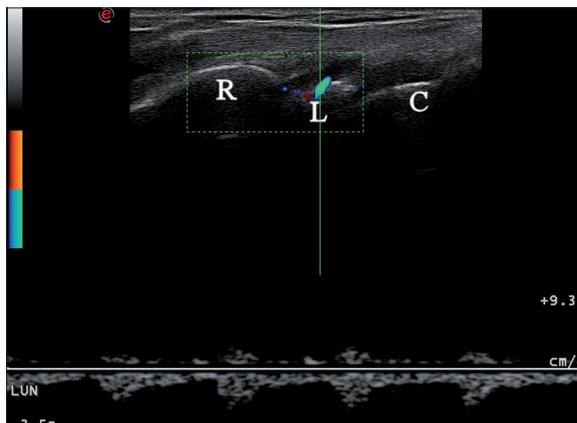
Spectral Doppler wave image obtained from blood vessel seen in lunate erosion, low-resistance type. Dorsal sagittal US image; R – distal part of the radius, L – lunate bone, C – capitate bone.
